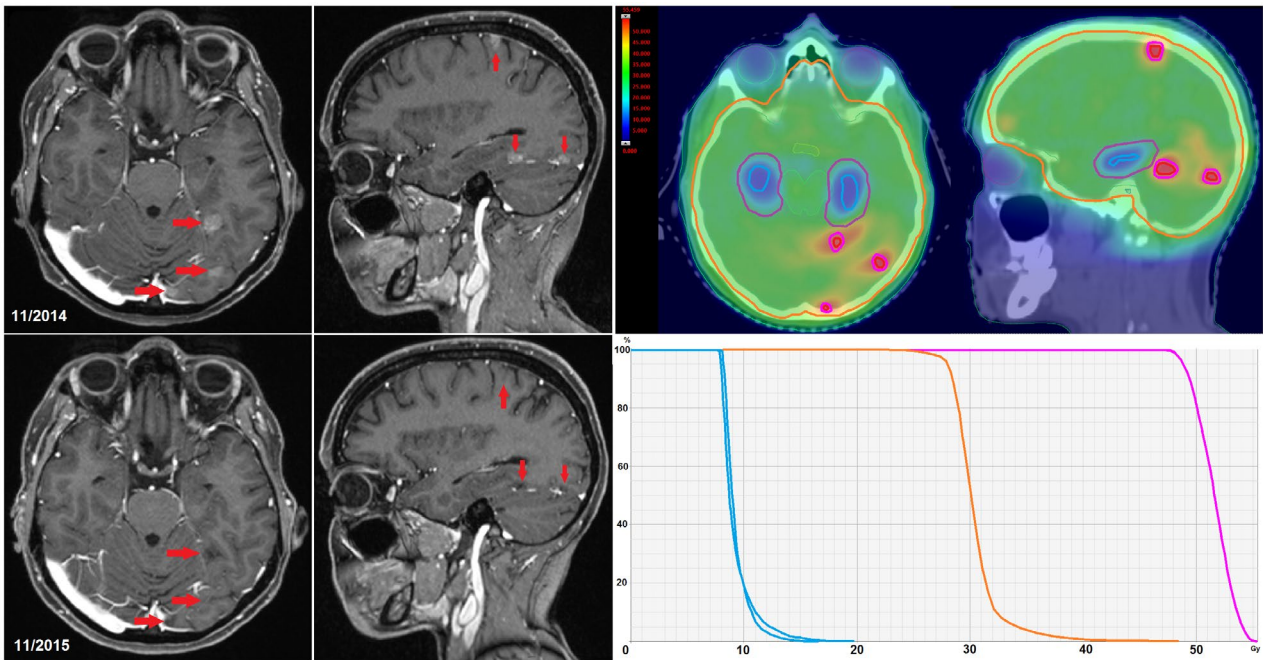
Example of a dose distribution and dose-volume histogram of an HA-WBRT+SIB plan for a patient with 15 brain metastases. Colors indicate the following: blue, hippocampi; purple, HAR; orange, $PTV_{\text{whole brain}}$ (whole brain + 3 mm – HAR – $PTV_{\text{metastases}}$); pink, $PTV_{\text{metastases}}$; green, brainstem; and yellow, optic chiasm. The mean dose in both hippocampi remained under 10 Gy, whereas the whole brain and the metastases received means of 30 and 51 Gy, respectively. The 1-year magnetic resonance imaging follow-up showed complete remission of the metastases. Arrows indicate three of the metastases before and after therapy. HAR indicates hippocampus-avoidance region; HA-WBRT+SIB, hippocampus-avoidance whole-brain radiation therapy with a simultaneous integrated boost; $PTV_{\text{metastases}}$, planning tumor volume of metastases; $PTV_{\text{whole brain}}$, planning tumor volume of the whole brain.
